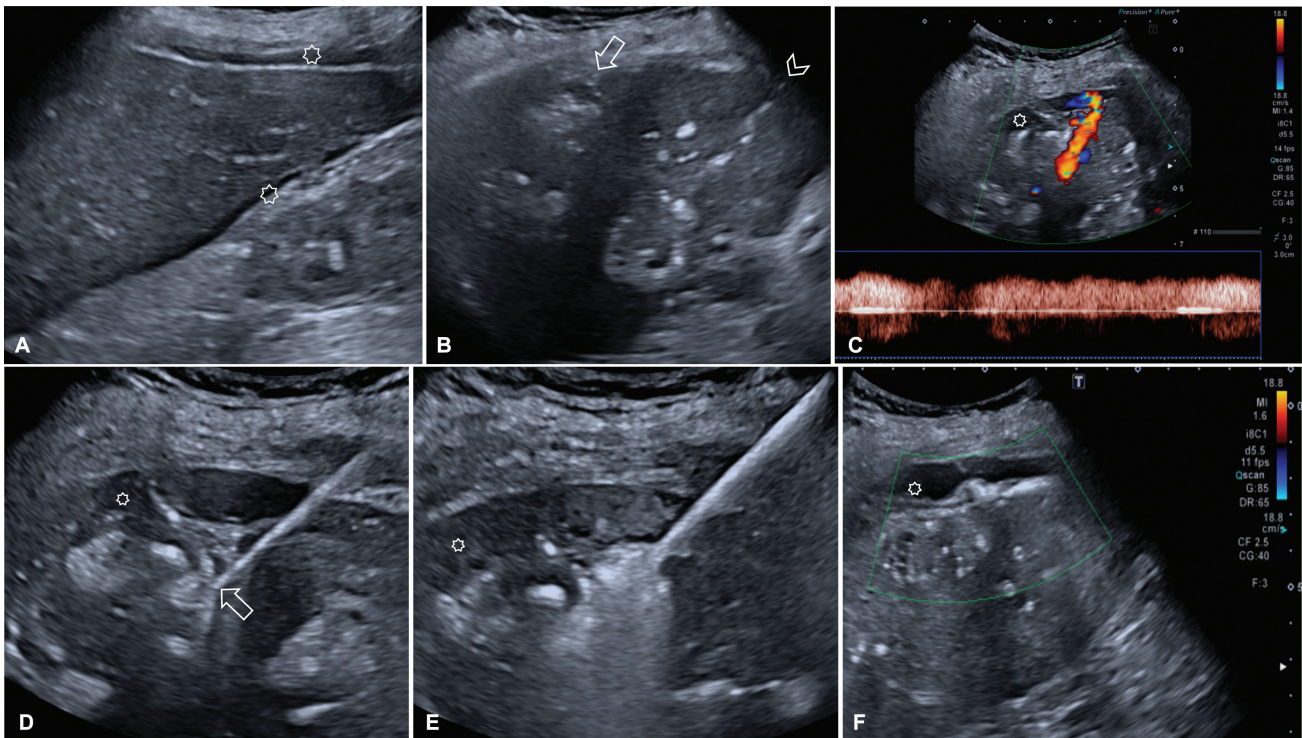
Images during ablation of bleeding needle tract. (A) Newly detected hepatorenal and perihepatic fluid (asterisk) after the removal of the microwave ablation (MWA) needle from the second puncture liver tract. (B) First (arrowhead) and second (arrow) sites of puncture of the liver capsule. (C) Color Doppler shows active extravasation from the second puncture liver tract with pulsation on spectral analysis. (D) Reinsertion of the MWA needle was done into the bleeding site and the needle tip is visualized (arrow). (E) After starting reablation of the bleeding tract. (F) No extravasation was detected on color Doppler after complete bleeding tract ablation.
